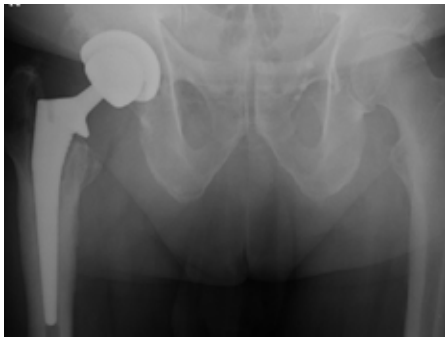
Preoperative AP radiograph of pelvis showing infected right THA. Preoperative aspiration grew *Staphylococcus epidermidis*. Note endosteal resorption of bone around proximal femoral stem.
